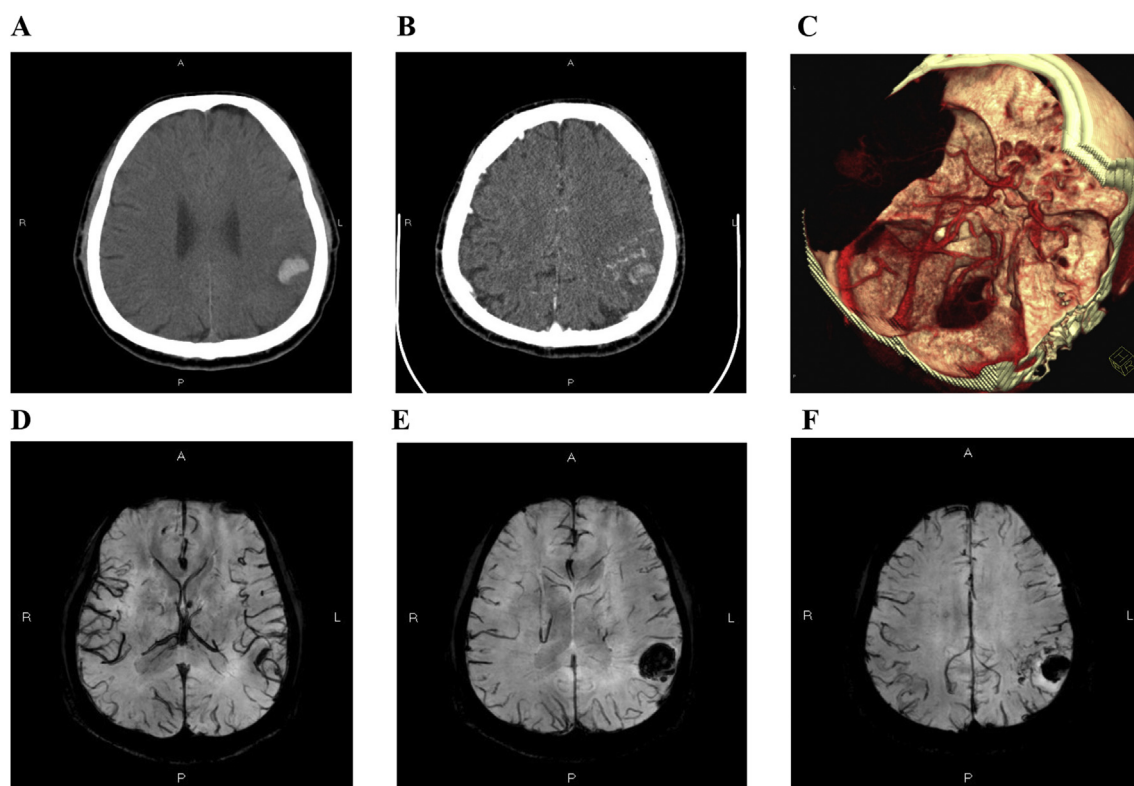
(A) Brain CT shows left parietal ICH; (B) and (C) brain CTA; (D), (E) and (F) SWI. Multiple surrounding engorged vessels are revealed.
